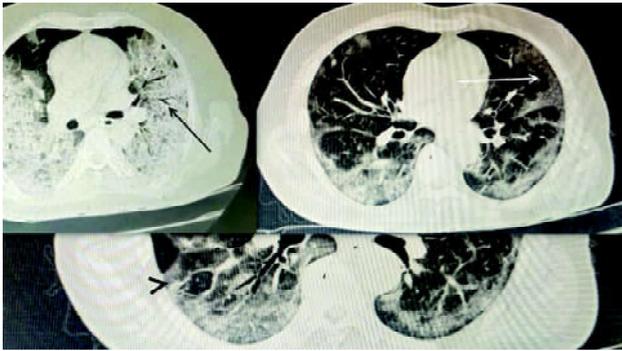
Some non-specific CT findings of COVID-19: air bronchogram (black arrow), peripheral based infiltrations (white arrow) and crazy paving appearance (black arrowhead) (GGO with superimposed thickened septal lines).
